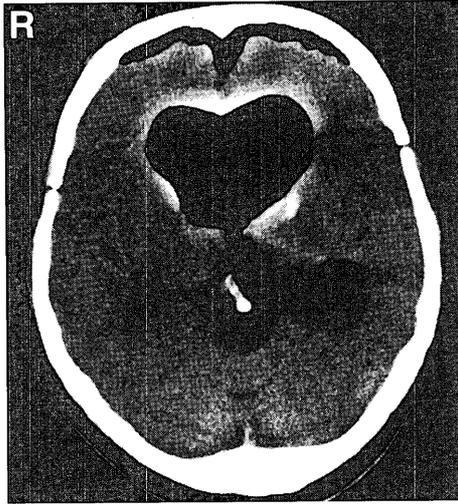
Postoperative computed tomography scan showing massive intraventricular collection of air and marked dilation of the ventricular system.
